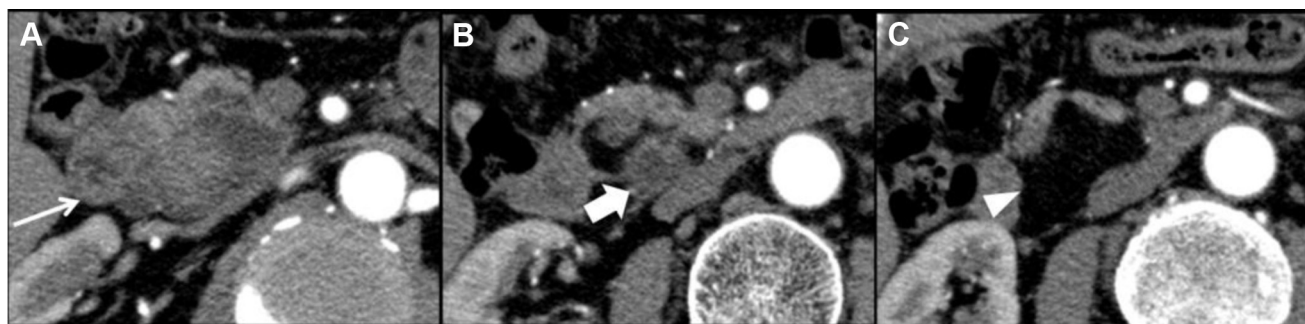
Contrast CT of the abdomen from the cranial (A) to caudal (C) direction. (A) 59-mm cystic lesion with a 23-mm enhanced nodule (arrow). (B) Soft-tissue nodule (wide arrow) within the lipomatous lesion located at the border between the cystic and lipomatous lesions. (C) Lipomatous lesion (arrowhead) is located caudal to the cystic lesion.
